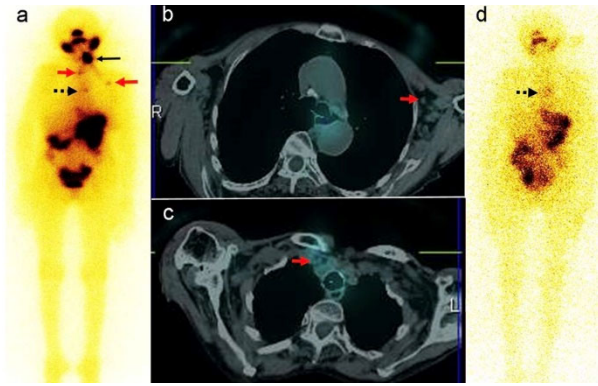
Post-therapy whole-body ^{131}I planar anterior image (a) and fused axial SPECT/CT (b,c) showing intensely tracer avid remnant (black arrow), faintly tracer avid left axillary, highest mediastinal (red arrows) and prevascular lymph nodes (broken arrow). Diagnostic whole-body ^{131}I planar anterior image (d) after 6 months showing resolution of remnant and left axillary lymph node with faint tracer uptake in the mediastinum (broken arrow)
